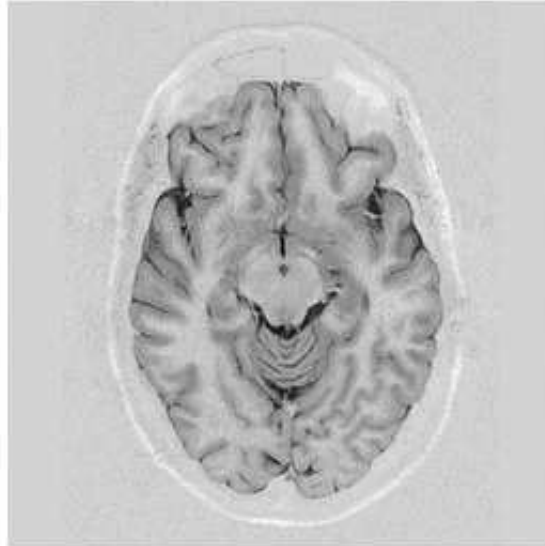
Typical slice from a fast spin-echo inversion recovery MR image volume.
